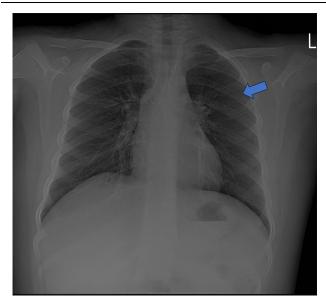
A post-bronchoscopic debulking chest X-ray.
